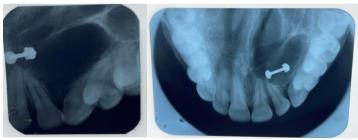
Image Showing Inverted Pear- Shaped Radiolucency (Fig 1) And Occlusal Radiograph Of The Maxilla Involving Same Region (Fig 2)
